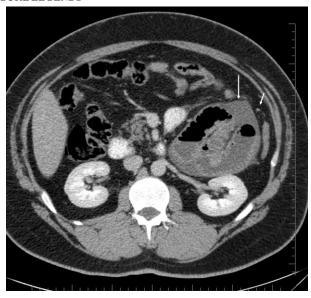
Oral and intravenous contrast enhanced MDCT images. Axial CT image from the mid-abdomen shows a saclike mass of dilated proximal jejunal segments in left upper quadrant next to the ascending duodenum. There is displacement of the inferior mesenteric vein anteriorly and laterally by the mass (short arrow). There is also free peritoneal fluid within the sac (long arrow).
